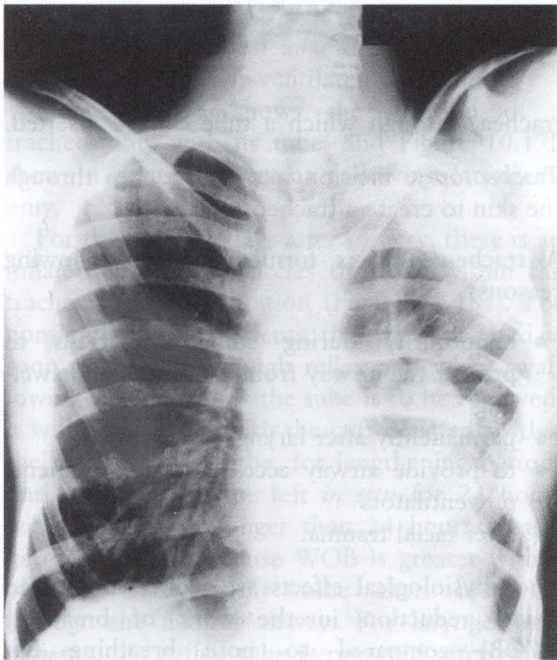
X-ray showing an empyema in the left upper zone that developed in a 17-year-old youth after oesophagectomy. In the left chest can be seen the cut rib of the thoracotomy and the colon transplant that replaced the oesophagus, partially filled with fluid.
